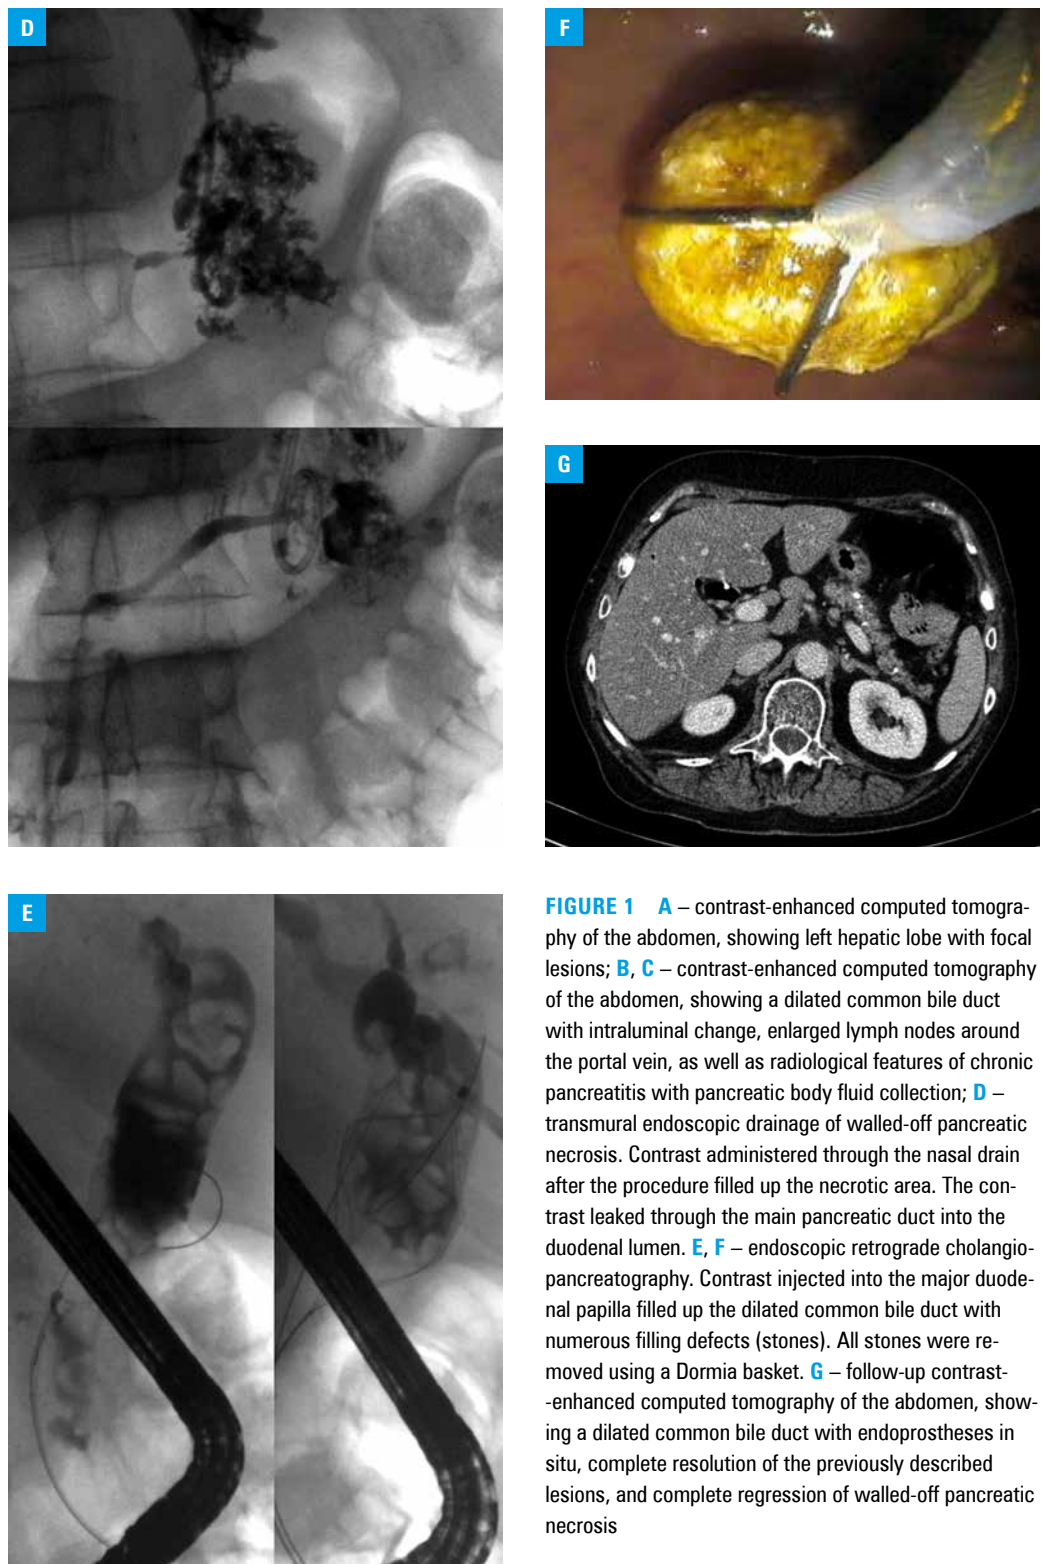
A – contrast-enhanced computed tomography of the abdomen, showing left hepatic lobe with focal lesions; B, C – contrast-enhanced computed tomography of the abdomen, showing a dilated common bile duct with intraluminal change, enlarged lymph nodes around the portal vein, as well as radiological features of chronic pancreatitis with pancreatic body fluid collection; D – transmural endoscopic drainage of walled-off pancreatic necrosis. Contrast administered through the nasal drain after the procedure filled up the necrotic area. The contrast leaked through the main pancreatic duct into the duodenal lumen. E, F – endoscopic retrograde cholangiopancreatography. Contrast injected into the major duodenal papilla filled up the dilated common bile duct with numerous filling defects (stones). All stones were removed using a Dormia basket. G – follow-up contrast-enhanced computed tomography of the abdomen, showing a dilated common bile duct with endoprosthesis in situ, complete resolution of the previously described lesions, and complete regression of walled-off pancreatic necrosis
